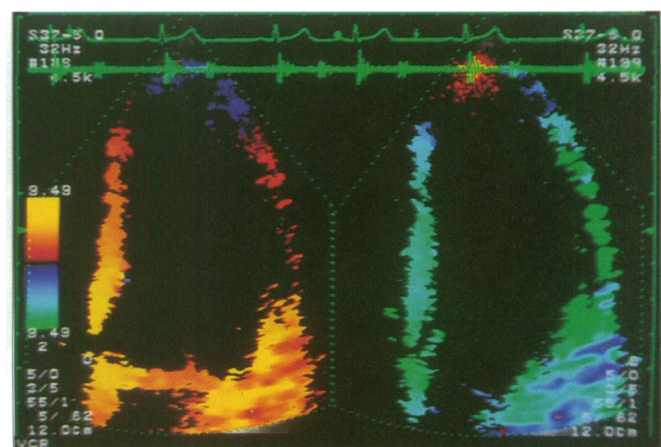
Apical four-chamber tissue Doppler echocardiogram, showing the normal pattern of relaxation and contraction. Myocardial velocities are highest in the base of the heart and decrease toward the apex, with reversal in the apical area. Note the synchrony of the septum and lateral wall as indicated by the same myocardial velocities in the opposite wall layers.
